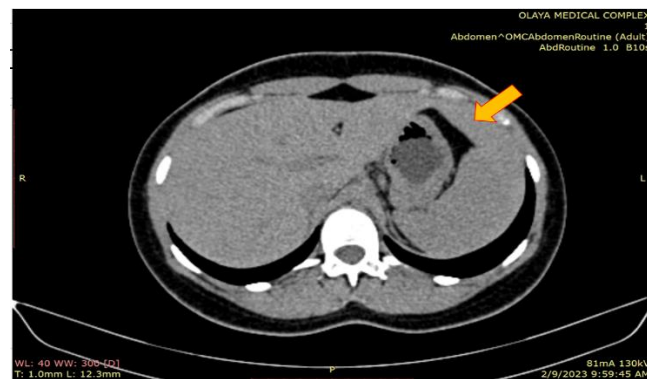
14 years old female - Axial non enhanced CT scan
